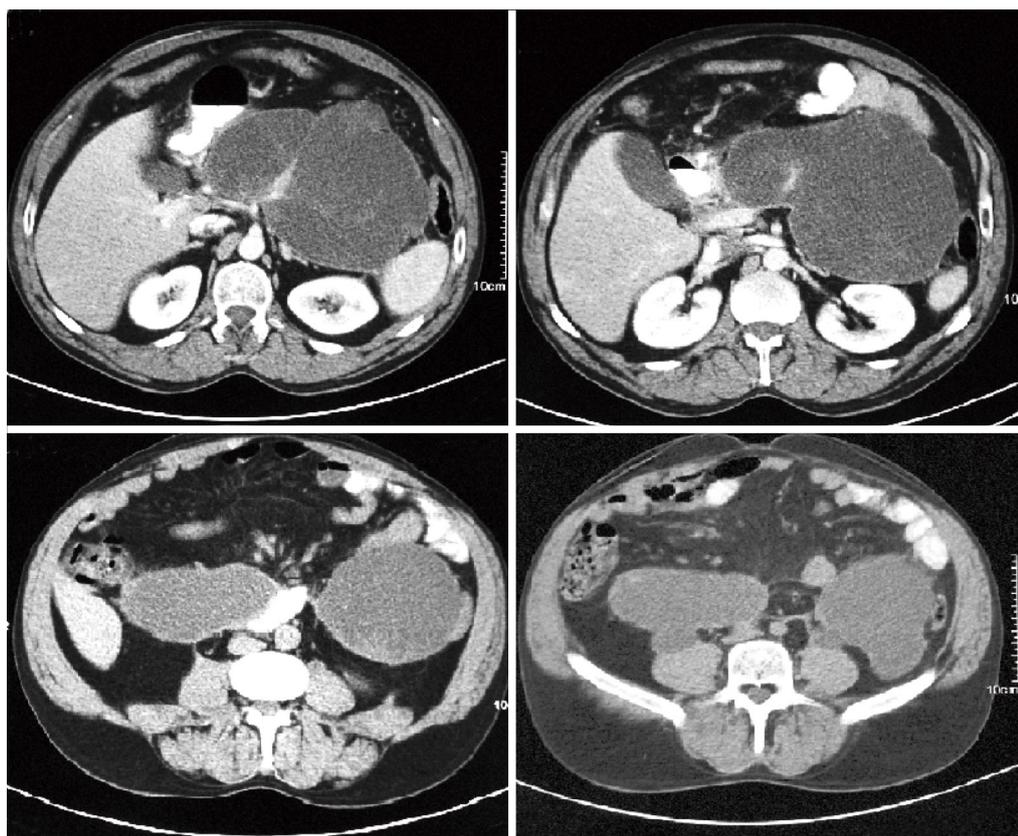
In this case, a large cyst of 18 cm in diameter with a horseshoe morphology going down bilaterally as far as the pelvic cavity can be seen on the CT scan.
